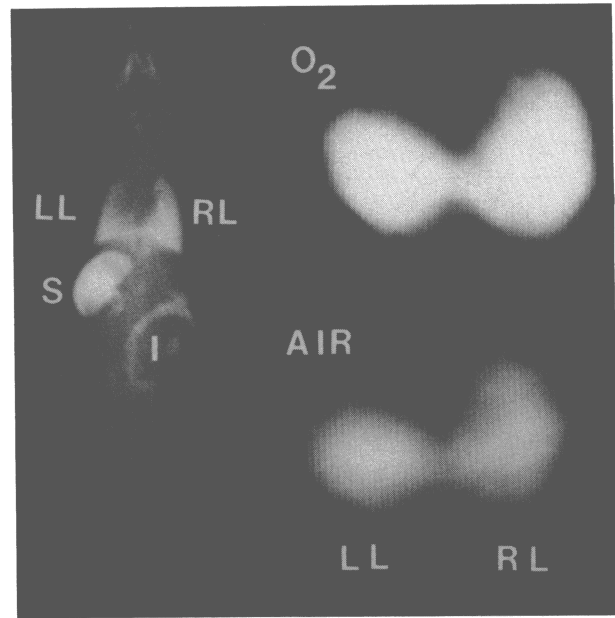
Radiograph (posteroanterior) (left) and transverse MR images (right) following liquid breathing of a 2-to-1 FC-75/PFOB mixture. The signal strength enhancement as a result of pure oxygen breathing is evident. Abbreviations: intestines, I; left lung, LL; right lung, RL; stomach, S. MR technique: 25.1 MHz (~0.63 T for fluorine); partial saturation, 150 ms recycle delay (TR); 128 averages/projection; 72 projections; gradient strength 0.09 G/cm.
